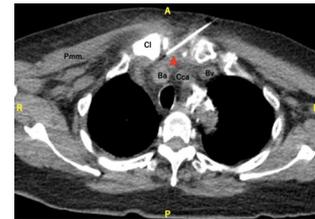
On admission, emergency CT-guided puncture drainage was performed for the sternoclavicular joint abscess (arrowhead). a, anterior; Ba, brachiocephalic artery; Bv, brachiocephalic vein; CCa, common carotid artery; Cl, clavicle; L, left; Pmm, pectoralis major muscle; P, posterior; R, right.
